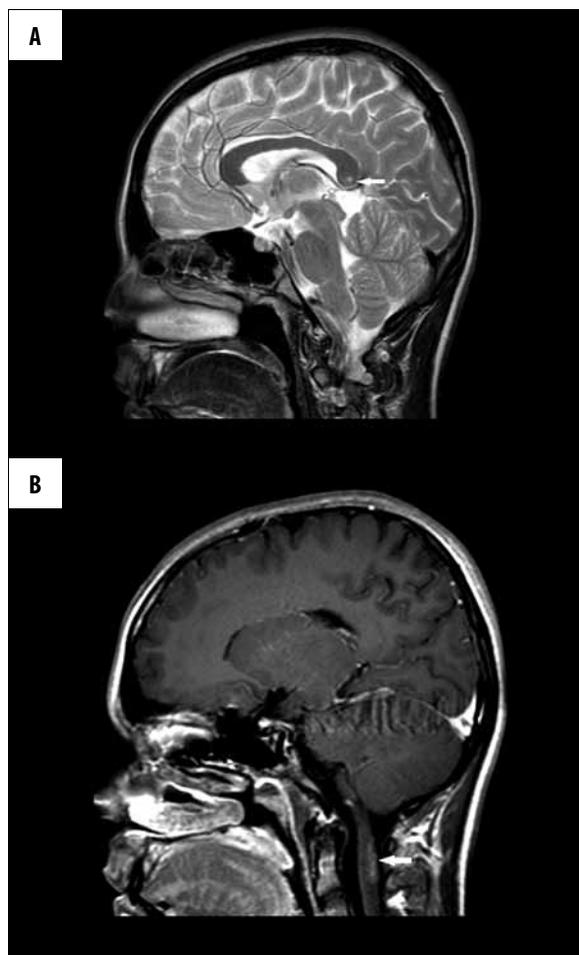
14-year-old girl, MRI brain scan. (A) T2-weighted FSE sequence image, sagittal plane – a single focus in the lobe of colossal commissure (arrow). (B) T1-weighted SE sequence image + CM, sagittal plane – a focus of demyelination on C2 level enhanced after the contrast, emphasizing spinal cord contour (arrow).
